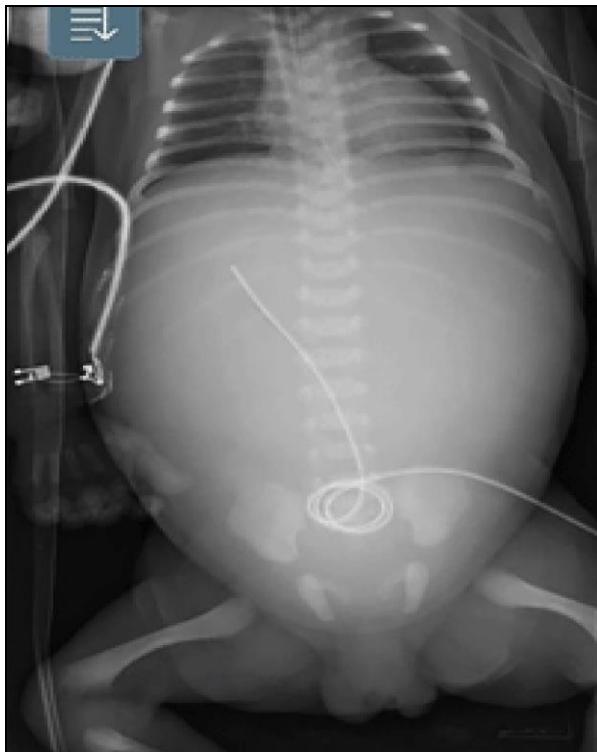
Postnatal first day no gas on abdominal X-Ray examination.
